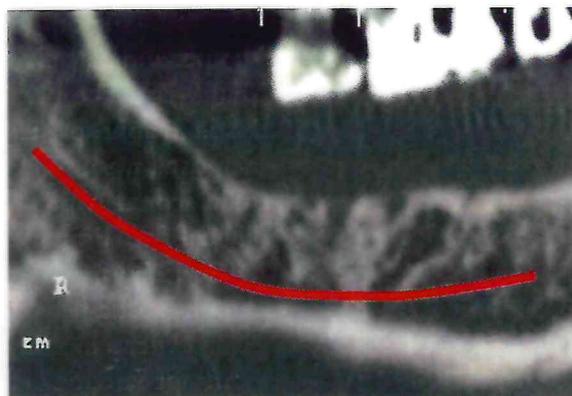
CT scan verifies that the location of the inferior alveolar nerve and the mandibular dimensions make the ramus a good donor site for a graft procedure.
